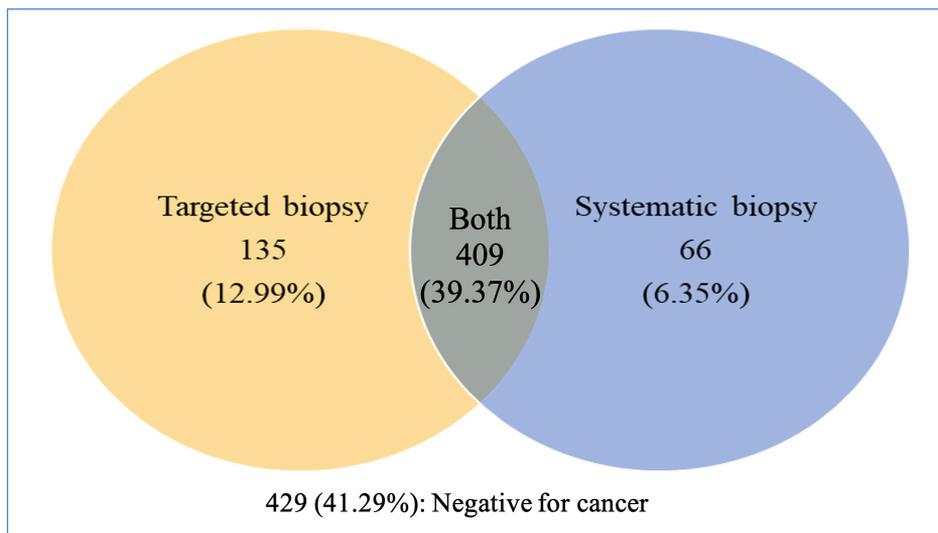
Cancer detection rate of MRI/US fusion prostate biopsy of 1,039 patients.
